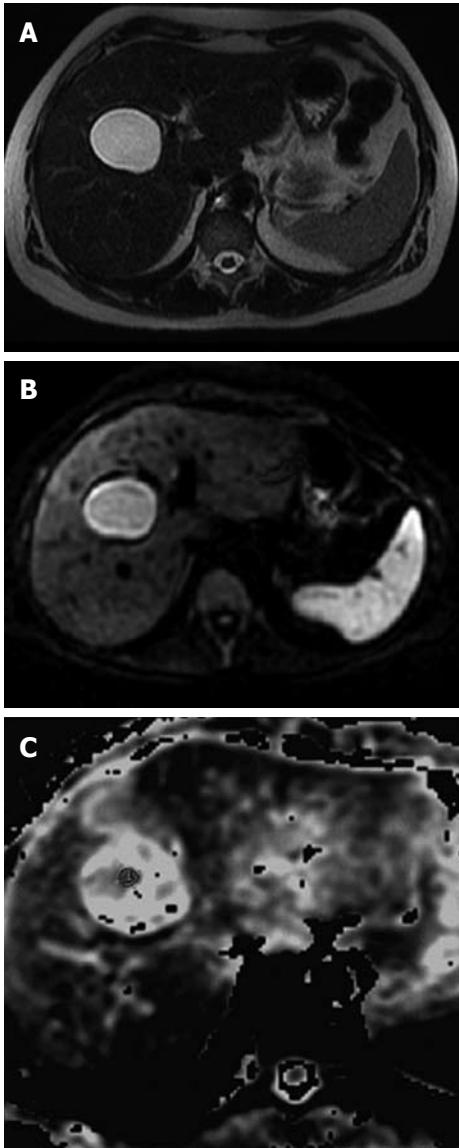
A type I hydatid cyst. A: Axial T2 weighted magnetic resonance image depicts a round cystic mass in the anterior segment of the right lobe, with no septa or solid portions; B: On the diffusion-weighted image the lesion exhibits high signal intensity ($b = 1000$); C: On apparent diffusion coefficient map, apparent diffusion coefficient value is 2.4×10^{-3} .
